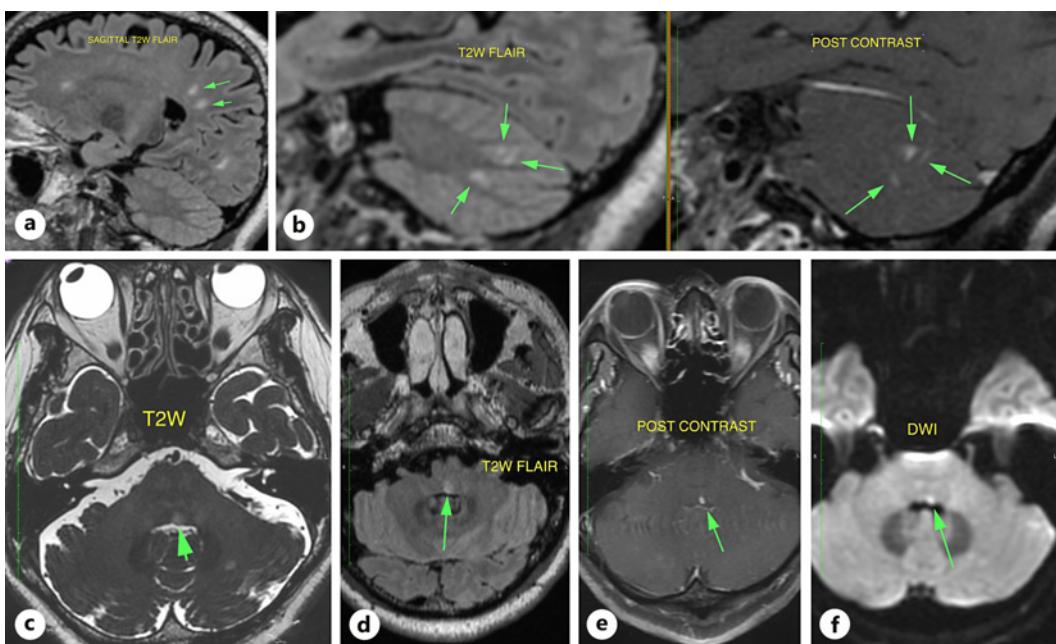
Brain MRI findings support diagnostic criteria for MS. Note the arrow. a Sagittal T2W FLAIR MRI showing hyperintense lesions in periventricular white matter perpendicular to the ventricles (Dawson's fingers) (arrow). b Sagittal T2W FLAIR MRI showing multiple small, round, hyperintense lesions in the left and right cortex and juxtacortical cerebellar hemisphere. The enhancement in post-contrast images. c-f Axial T2W and T2W FLAIR MRI showing small hyperintense lesion in the left paramedian pontine reticular formation (PPRF) area in the dorsal of pons (arrow). The enhancement in post-contrast and diffusion-weighted imaging.
